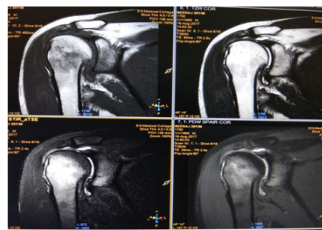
MRI coronal (A) T1 W (B) T2 W (C) STIR and (D) PDW images showing complete chronic supraspinatus tear with proximal tendon retraction and atrophy of muscle bulk.
